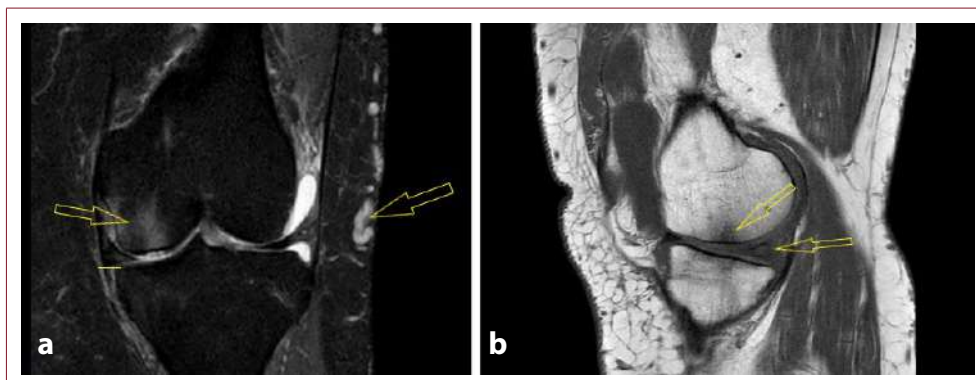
Magnetic resonance imaging of the knee. (a) Coronal fat-suppressed image demonstrating an osteochondral lesion with subchondral bone marrow edema on the weight-bearing surface of the medial femoral condyle (arrow), medial meniscal extrusion (line), and multiple dilated serpiginous venous structures within the periarticular soft tissues suggestive of a venous malformation (arrow). (b) Sagittal image demonstrating an osteochondral lesion of the medial femoral condyle (arrow) and a longitudinal tear of the posterior horn of the medial meniscus (arrow).
